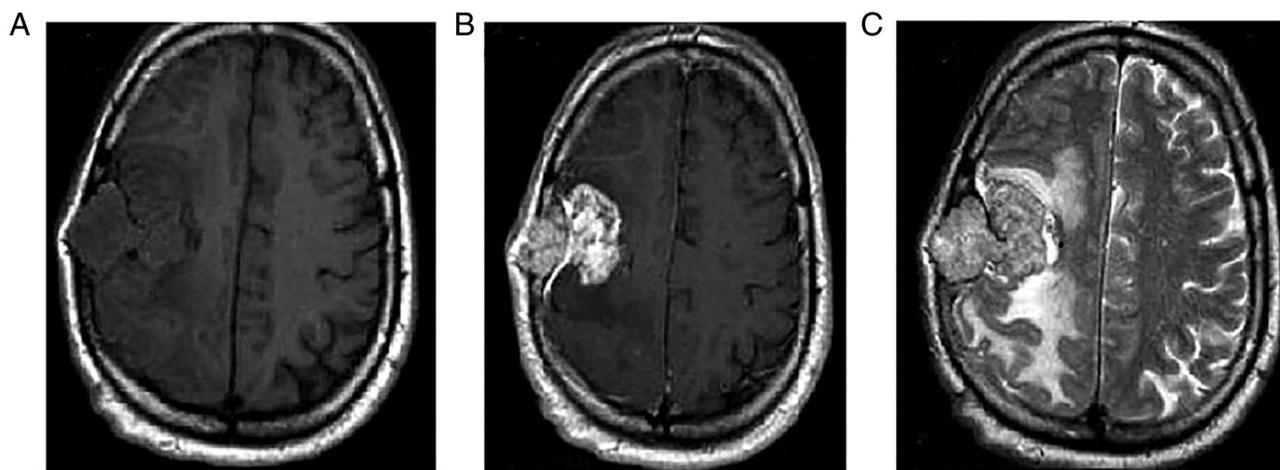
Case 2. (A) Axial T1-weighted image before contrast administration. Specifically, iso-intensity to slight hypo-intensity relative to grey matter were observed. (B) Axial post-contrast T1-weighted image revealed an extra-axial mass on the right cerebral convexity. The mass exhibited avid, homogeneous enhancement with occasional areas of central necrosis and with the dural tail sign. (C) Axial T2-weighted image revealed a mass with mixed iso- and hyperintensity on the right cerebral convexity.
